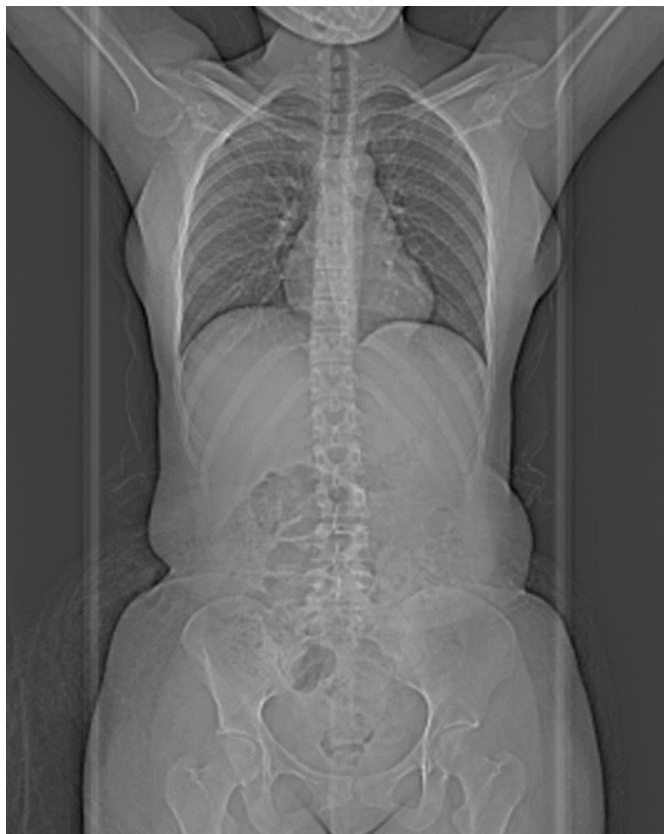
CT scan of patient – notice her slender build
